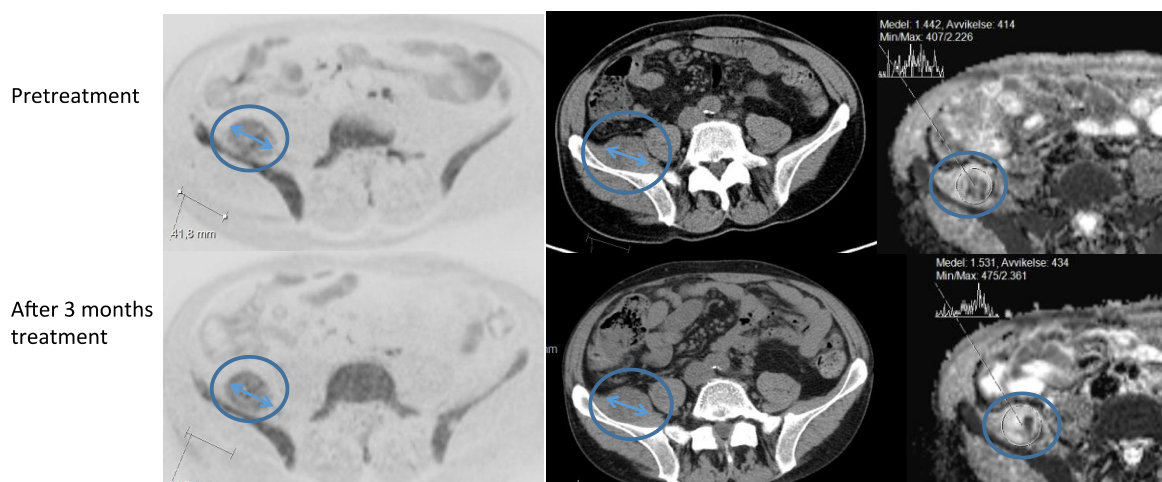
The longest dimension as determined by DWI (to the left) and CT (in centre) was measured and compared before and after treatment. An ADC map (to the right) confirmed the identification of malignant lesions by DWI.
